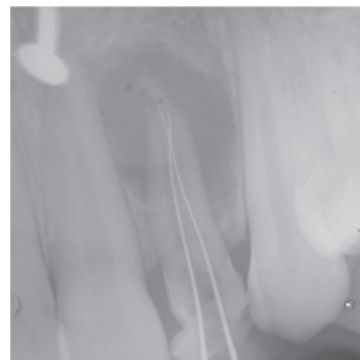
Working length radiograph confirmed the presence of two separate root canals.
